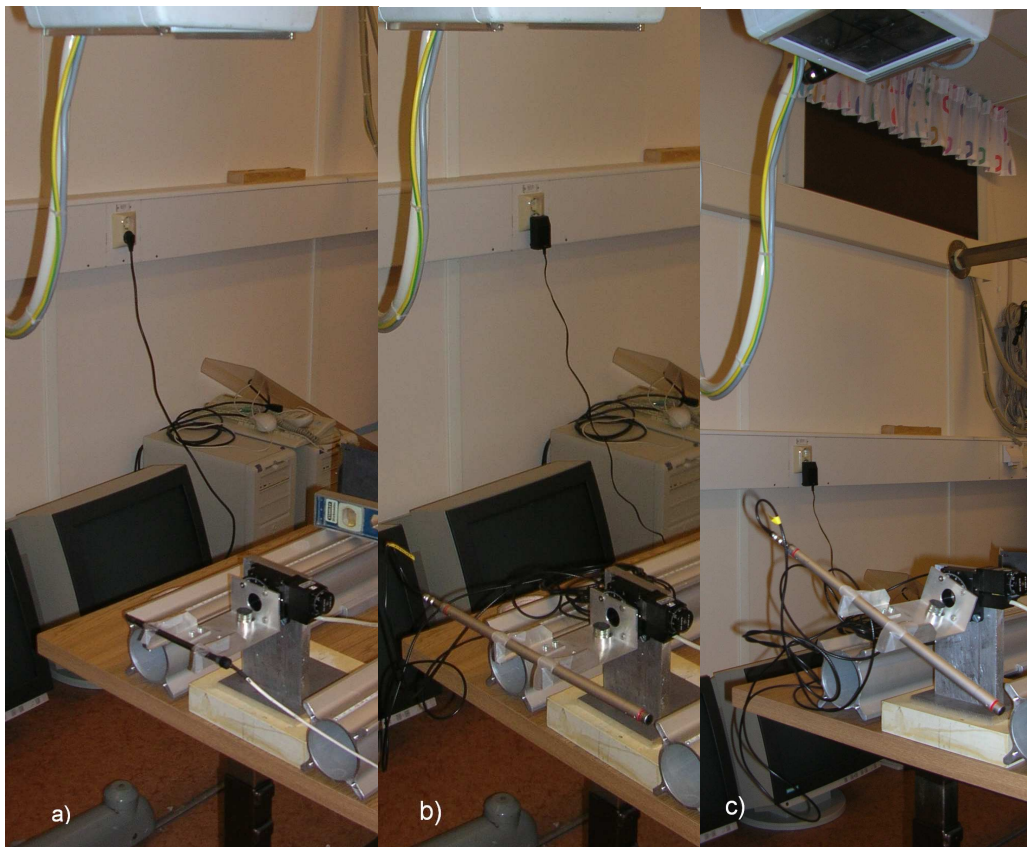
Angular dependence measurements on a) the pencil ion chamber, b) the CT-SDD2 (2x2), c) the CT-SDD2 (2x2) with a large angle.
